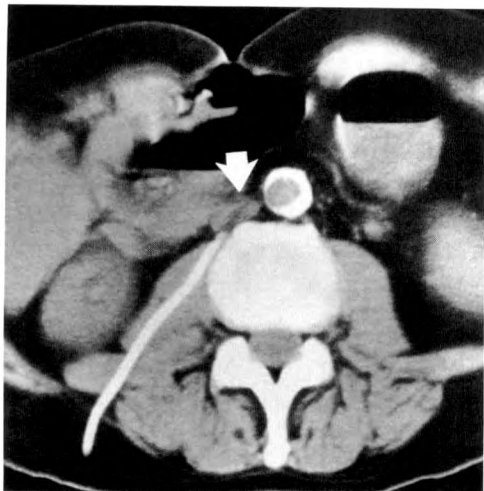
CT scan. Catheter passes through psoas muscle between spine and kidney, entering inferior vena cava (IVC) (arrow). Note absence of hematoma around IVC or in psoas muscle.
